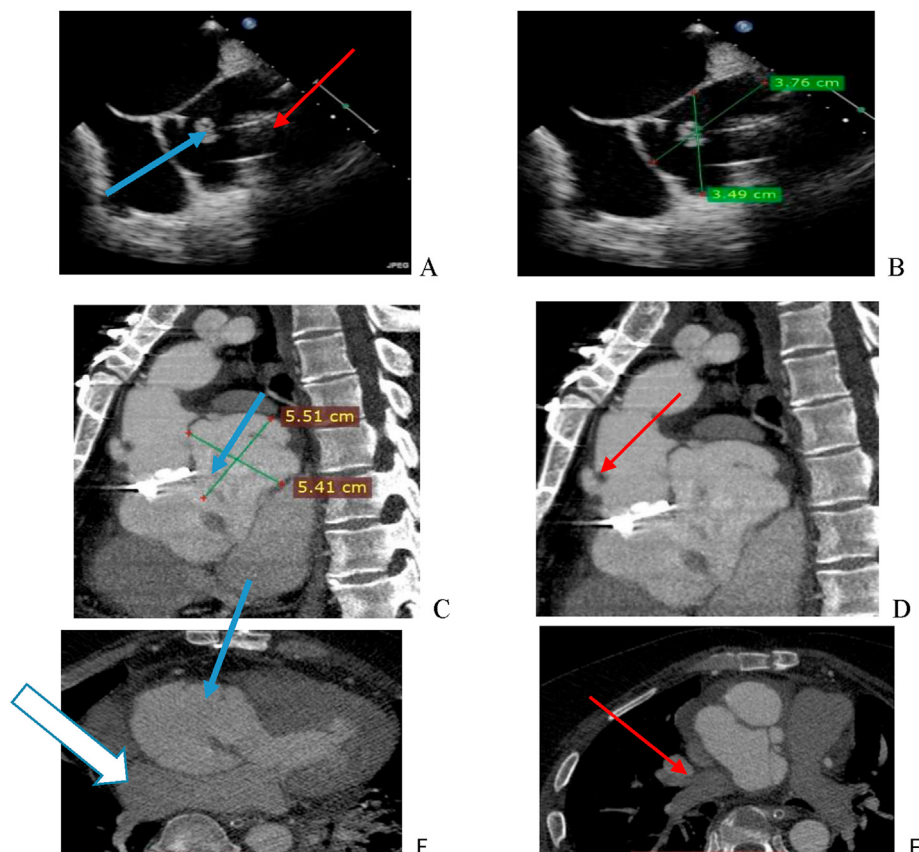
CT detects aortic root pseudo aneurysms and relation to surrounding structures (small pseudo aneurysm was missed by TEE) (A): TEE, Mid esophageal short axis view showing large aortic root pseudoaneurysm (White arrow) with ill-defined borders and relations by TEE and multiple small mobile masses (Blue arrow) mostly vegetation. Red arrow refers to aortic mechanical prosthesis. (B): TEE, Mid esophageal short axis view showing large aortic root pseudoaneurysm measuring 3.76 × 3.49 cm. (C): MCTA, Sagittal cut, long axis view showing huge aortic root pseudoaneurysm measures 5.5 × 5.4 cm in its largest dimensions related to the posterior aspect of the aorta and communicate with left ventricle outflow tract with large neck (blue arrow). (D): MCTA, sagittal cut, showing another smaller aortic root pseudoaneurysm (red arrow) related anterior wall of the ascending aorta at the ostium of the right coronary artery. (E): MCTA, axial cut, showing huge aortic root pseudoaneurysm (blue arrow) and its relation to surrounding cardiac structures, compresses left atrium (White arrow). (F): shows indentation of right pulmonary artery (red arrow) by huge aortic root pseudoaneurysm.
